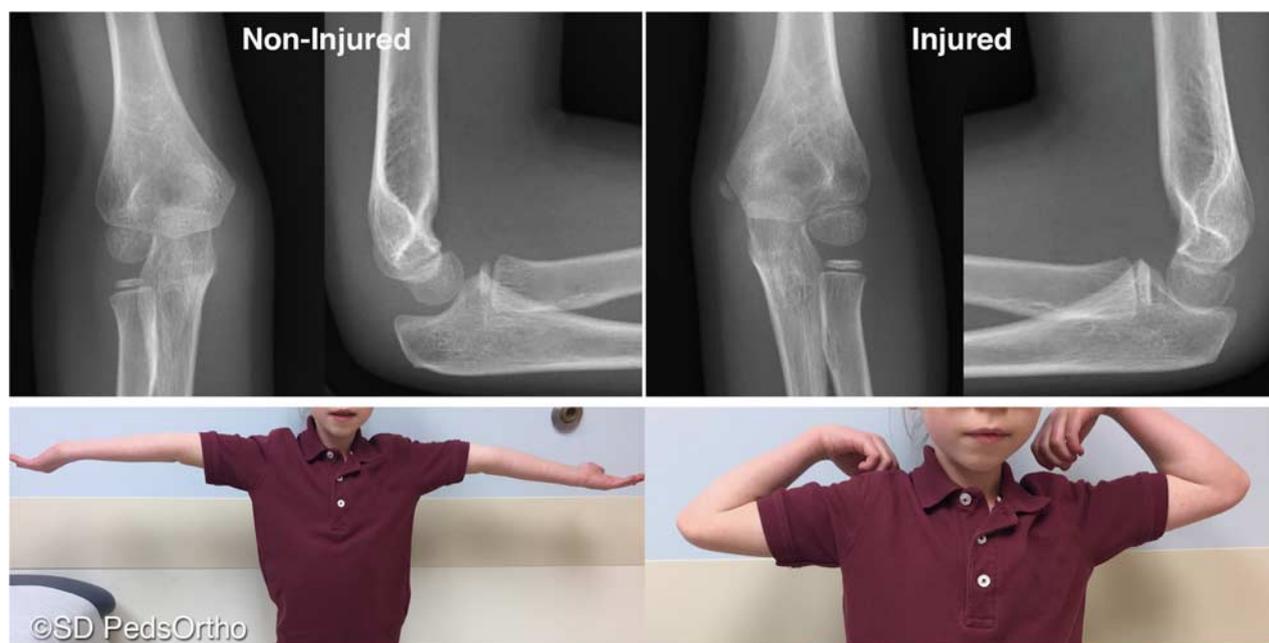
Case example of a nonoperative patient with mild hyperextension and loss of flexion compared with the contralateral side. Radiographs and clinical photos taken at 6-month postinjury.
